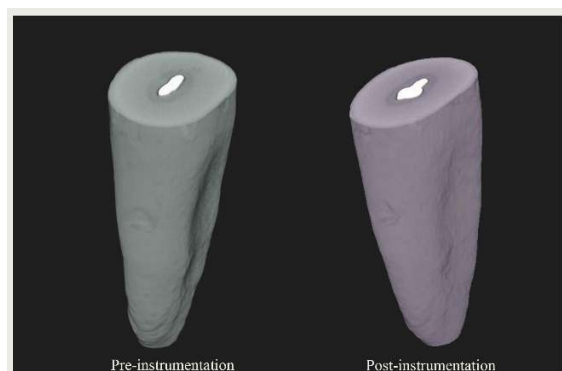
Microcomputed tomography reconstructions of the root before and after root canal instrumentation.
